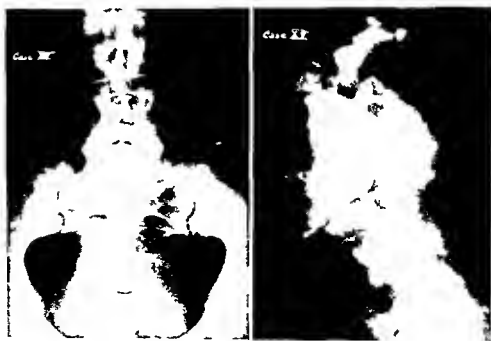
Roentgenograms Case 15. Lesion of isthmus with third degree spondylolisthesis.
